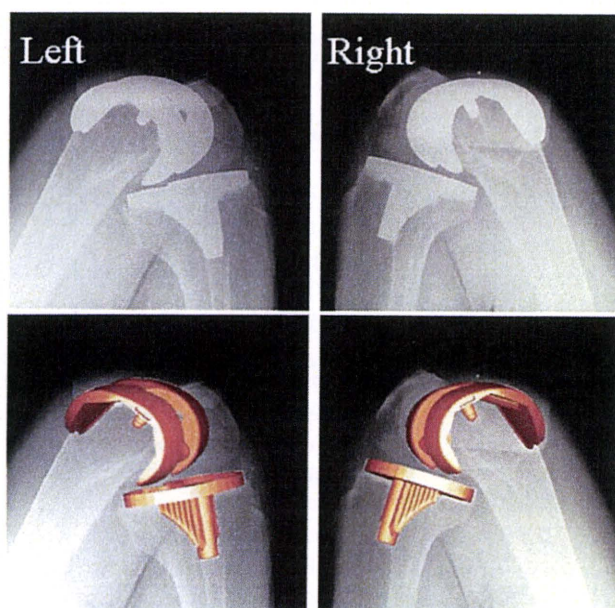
Shape-matching data of *seiza*-style sitting 3 months after TKA. Left radiographs show 3-dimensional position and orientation of the implant as measured by model-based shape-matching techniques. Right table shows articular surface separation and rotation between polyethylene insert and femoral component.
